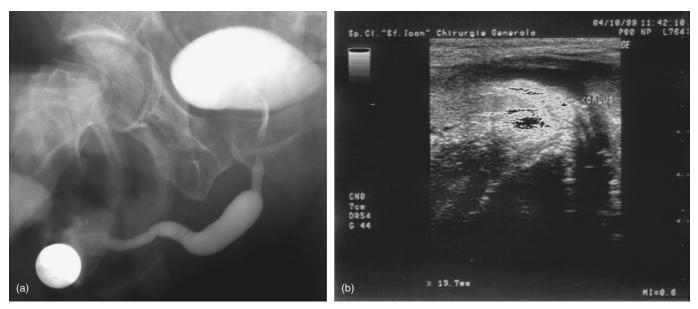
Stricture of the bulbar urethra (a) with spongiofibrosis at 12 o'clock seen at ultrasound exam (b).
